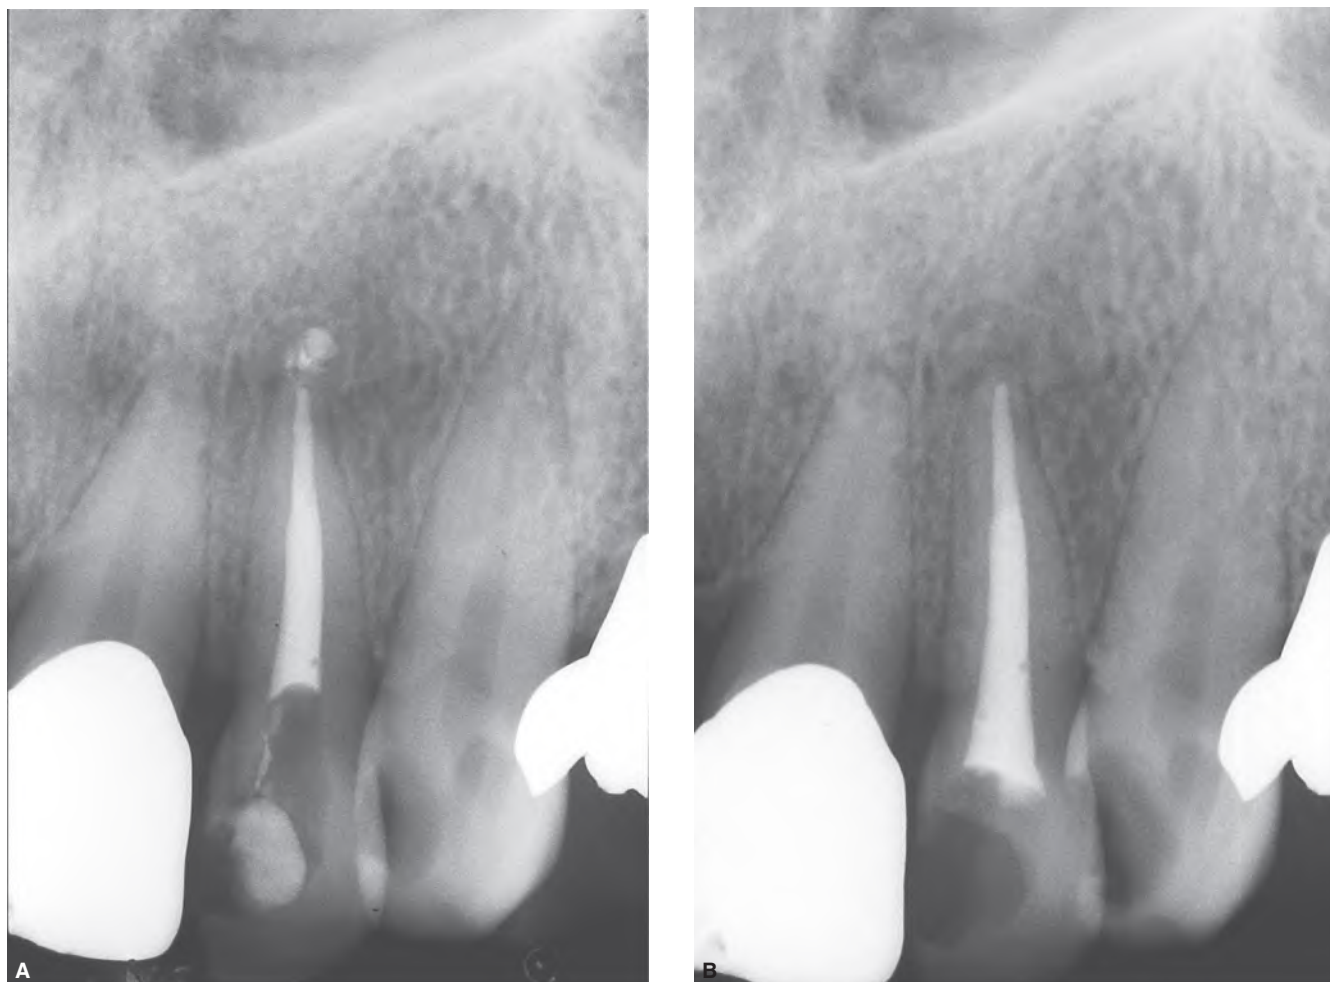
A.* Postoperative radiograph of a maxillary left lateral incisor treated endodontically. Note extruded material (probably sealer) beyond the apical foramen. *B.* Radiograph taken 7 months later showing the excess material has disappeared.
